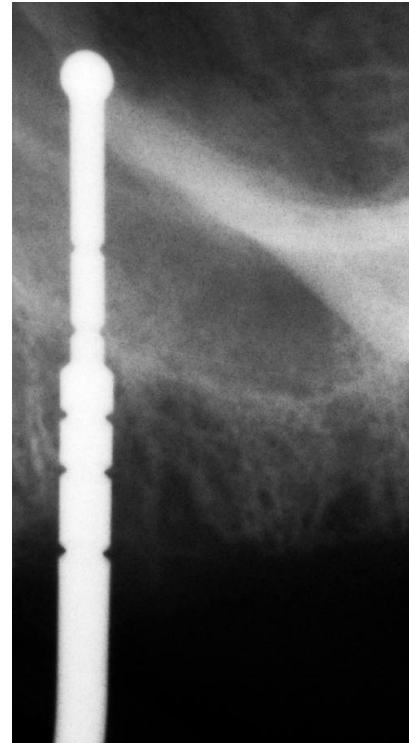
Periapical radiograph showing the depth gauge penetrating the sinus floor.
